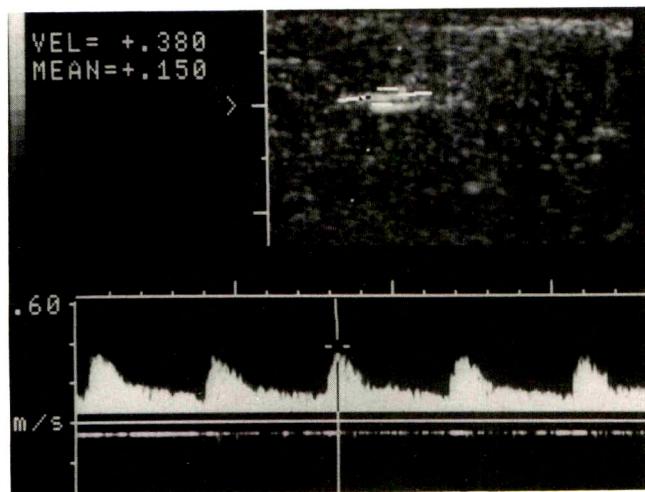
Normal cavernosal artery. Duplex sonogram with Doppler gate placed over cavernosal artery (top) and spectral waveform (bottom). Caliper indicates peak systolic velocity is 38 cm/sec. Measurement is calculated from Doppler shift, corrected for angle of long axis of cavernosal artery with respect to incident Doppler pulse.
